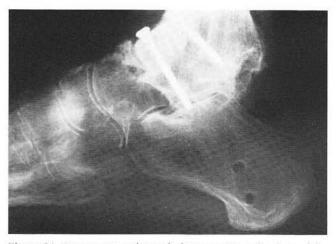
Preoperative radiograph demonstrating arthrodesis of the ankle joint with internal fixation advancing to the posterior facet of subtalar joint.
